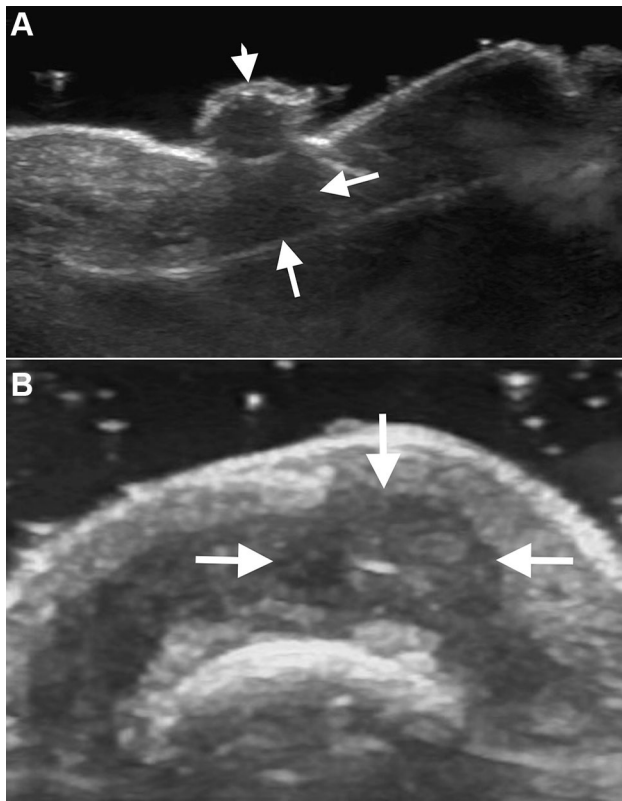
Fibrokeratoma or Koeneńs fibroma. Ultrasound a longitudinal and b transverse views. There is a hypoechoic, hypovascular, round, eccentric, lesion located in the proximal third of the nail bed with extension to the nail matrix (*arrows*). An exophytic component is seen as a polypoid, hypoechoic and hypovascular lesion involving the proximal nail fold (*arrowhead*)
